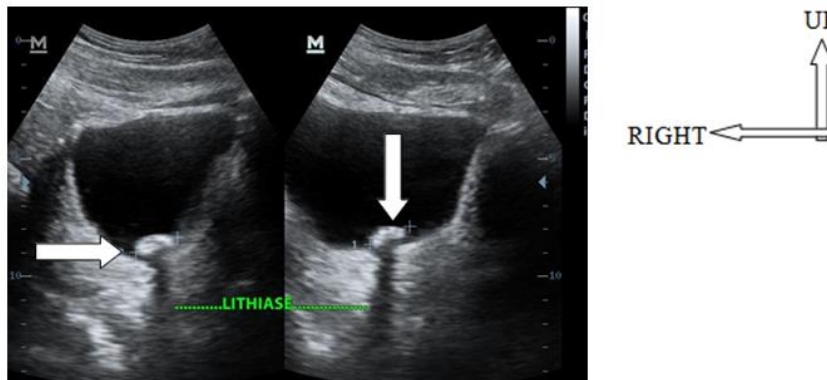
Pelvic ultrasound in cross section in a 42-year-old man revealing a hyperechoic image in the bladder with a posterior shadow cone: bladder lithiasis
